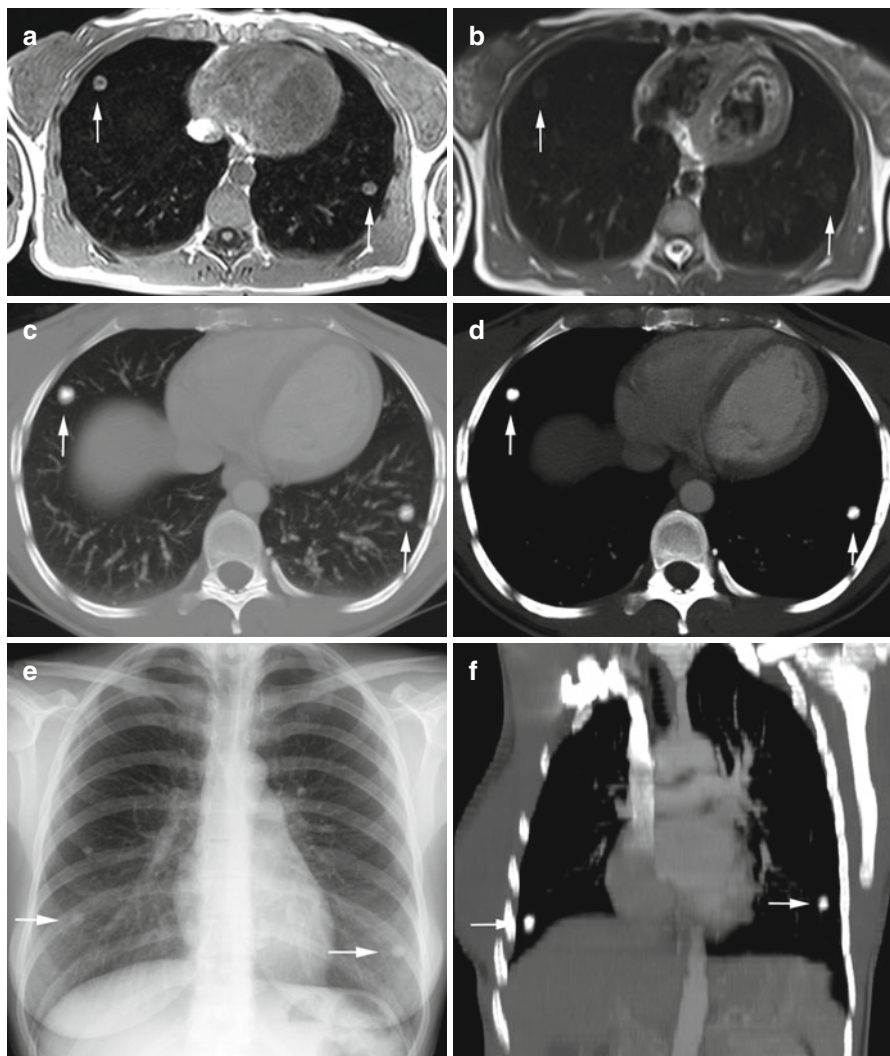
Incidental multiple pulmonary nodules with diagnostic workup in a 37-year-old female subject. T1w image shows a 13-mm lesion in the right middle lobe and a 12-mm lesion in the left lower lobe (a); the lesions have high-signal-intensity rims with less intense centers. The lesions are difficult to see on T2w HASTE image (b). Workup with CT (c, d, f) and conventional radiography (e) demonstrates homogeneously calcified nodules. Diagnostic resection (VATS) confirmed post-tuberculous granulomas
